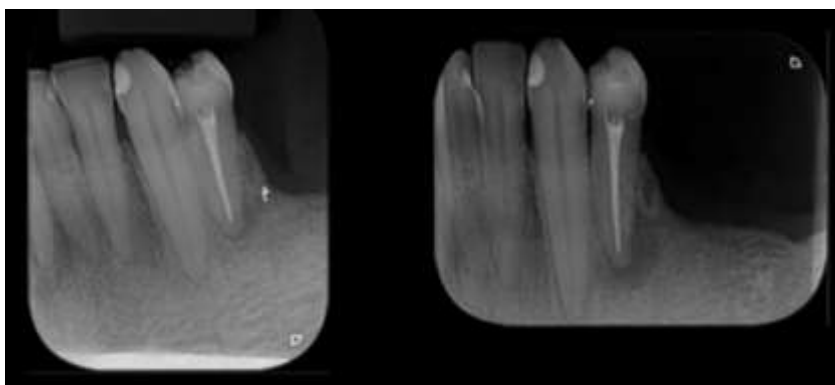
Periapical lesion associated with the root apex of element 34 after 1 year and 10 months.
